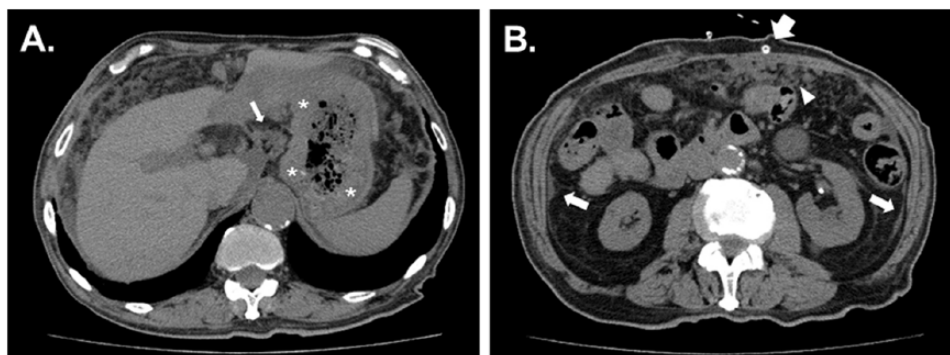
The results of the abdominal CT examination. Select images of the CT scan (A, B) revealed the thickened gastric wall (asterisks) and enlarged lymph nodes (narrow arrow) along the lesser curvature to the antrum of the stomach. A nodular soft tissue lesion in the omentum (arrowhead) and enhanced peritoneal thickening (middle arrows) were also confirmed. The PD catheter within the wall of the abdomen is indicated (wide arrow). CT indicates computed tomography; PD, peritoneal dialysis.
